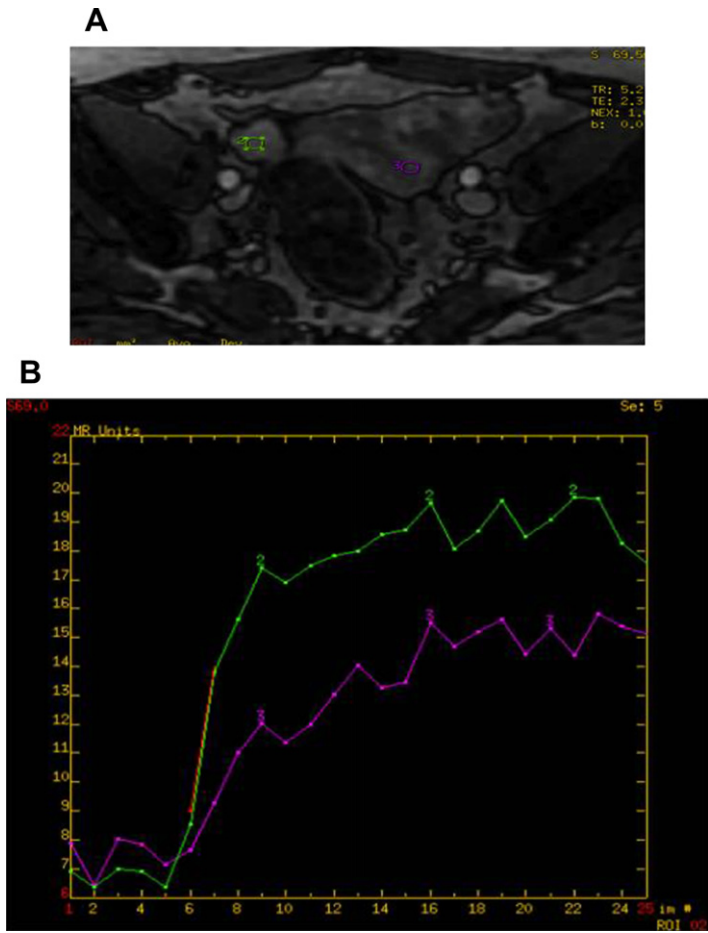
Sertoli-Leydig tumor. Dynamic contrast imaging shows type III curve. (A) DCE-MR imaging. (B) Dynamic curve.
